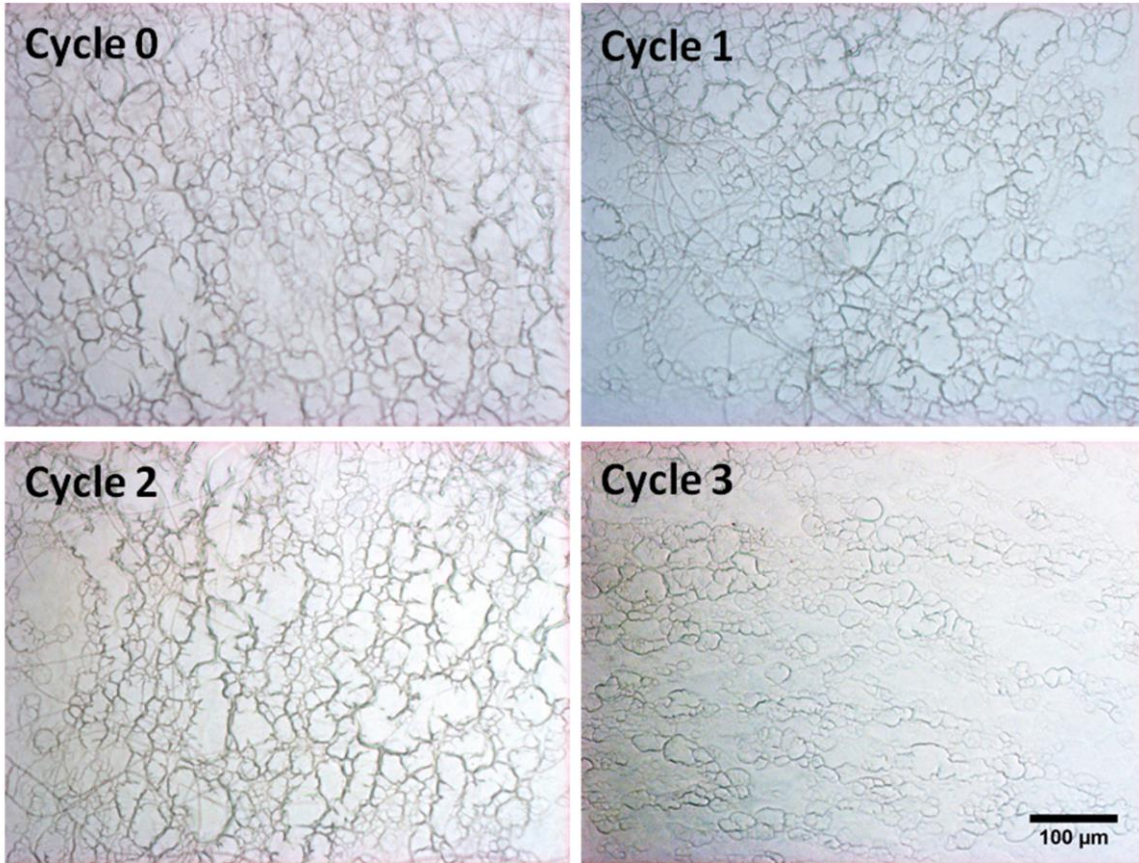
Examination of hFDM stability on PVA/hFDM membrane. The anchorage of hFDM to PVA hydrogel is evaluated using ultrasonication. Each cycle consists of high power ultrasonication for 5 min at 25 °C. After treatment, the persistence of fibrous hFDM structure was observed on the surface of PVA hydrogel. Scale bar is 100 μm .
